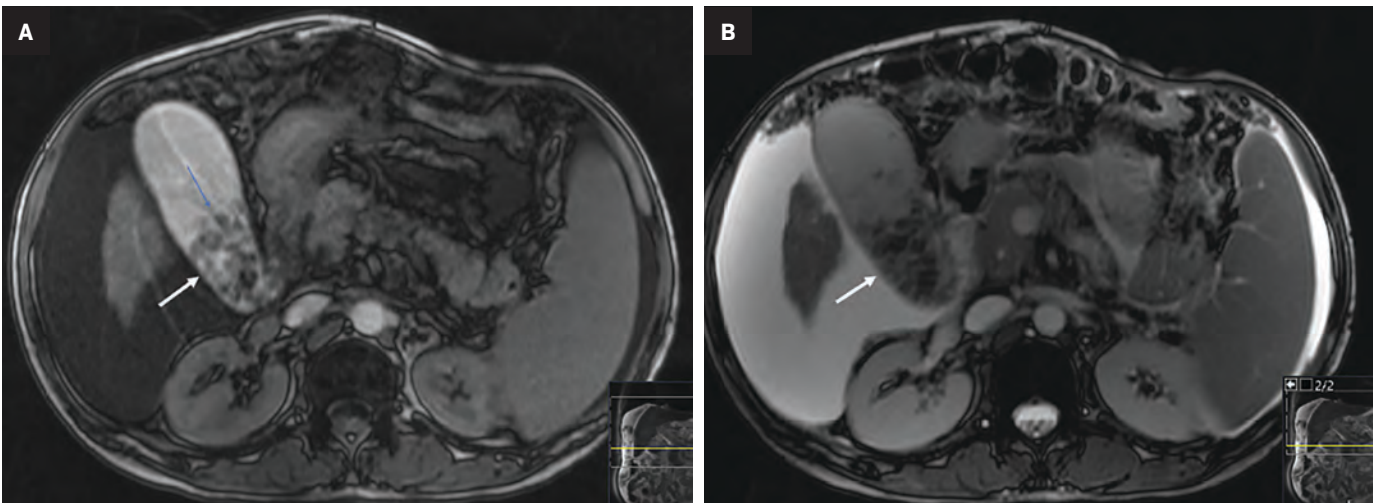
Axial (A) T1 and (B) T2 MRI of the upper abdomen show the enlarged gallbladder with its very viscous content and cholelithiasis (arrows). Note the large amounts of intraperitoneal fluid and cirrhotic liver.
